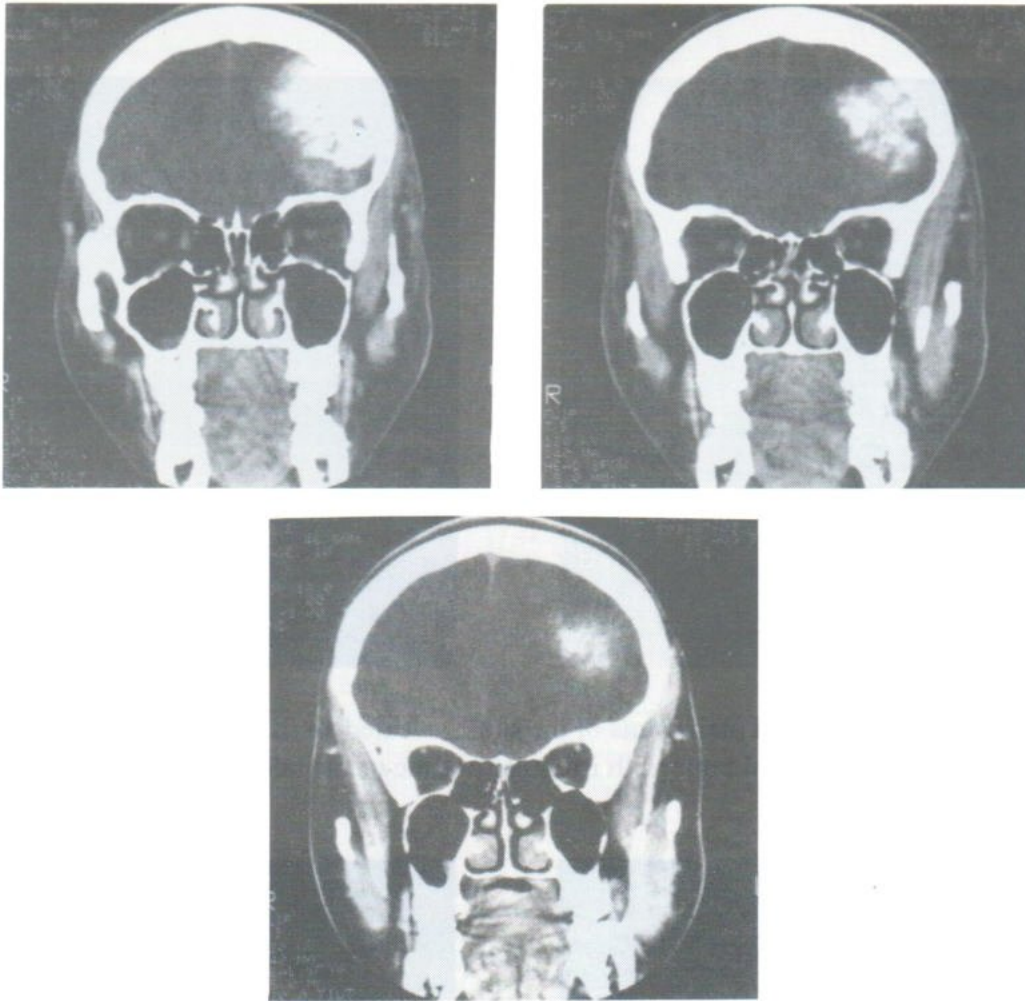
Case 1. CT scan of the lesion showed that the lesion contained heavy calcification.
